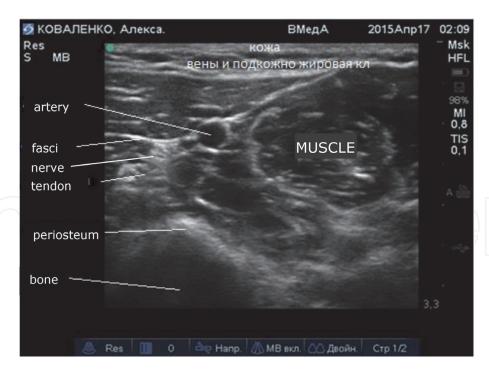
Indicative ultrasound picture with symbols. Screen view of Edge (FujiFilm SonoSite Inc.'s handheld ultrasound machine).
